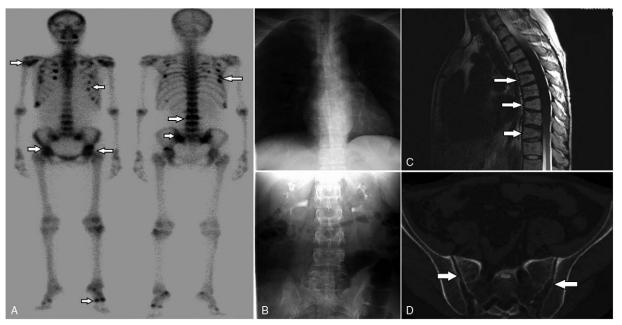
(A) whole body bone scintigraphy showed multiple foci of increased radiotracer uptake in the shoulder, multiple ribs, thoracic and lumbar spines, bilateral sacroiliac joints, left ilium, and left foot (arrow). (B) Plain radiographs revealed osteoporosis change of thoracic and lumbar spine as well as compression change of several spine. (C) MRI demonstrated osteoporosis and compression change of several thoracic spines (arrow). (D) CT showed degenerative changes and low bone density in the bilateral sacroiliac joints (arrow). CT = computed tomography, MRI = magnetic resonance imaging.
